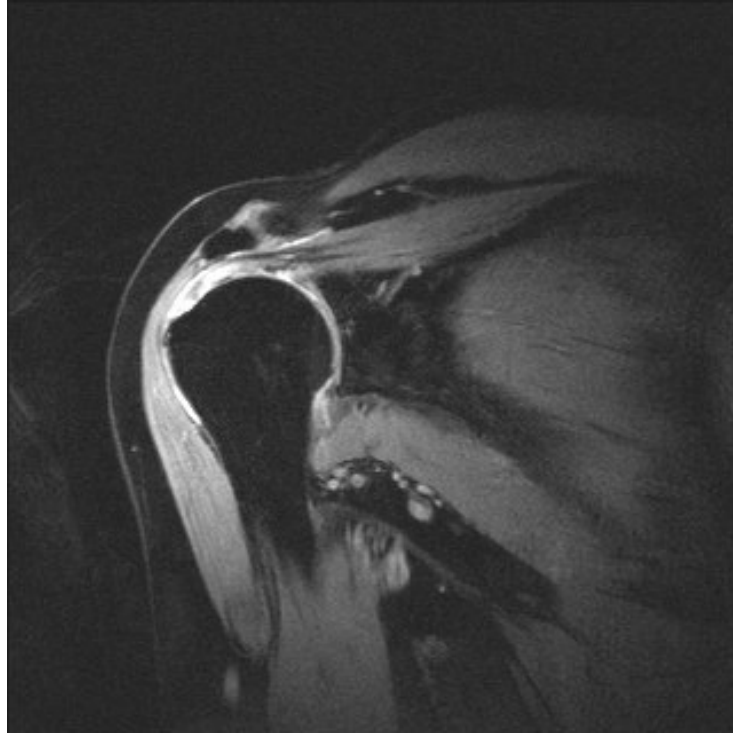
Preoperative MRI picture showing full thickness cuff tear
